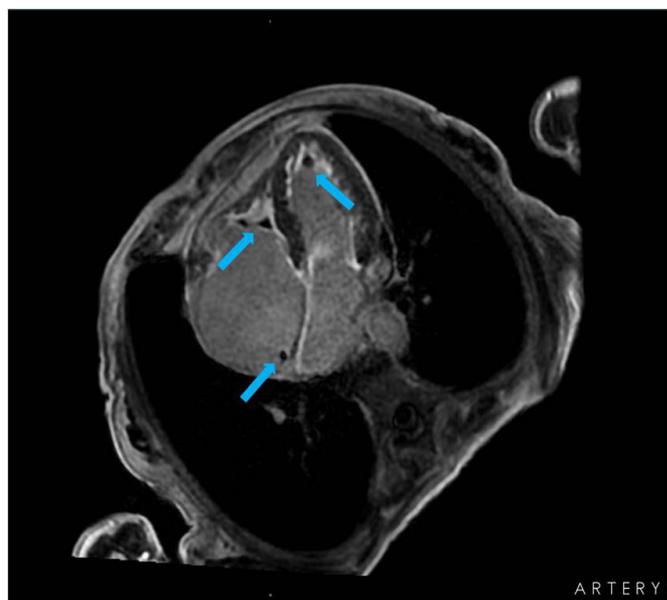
Cardiac magnetic resonance imaging revealing presence of four intracardiac thrombi located in the right and left ventricular apex, right atrium and right atrial auricle.
